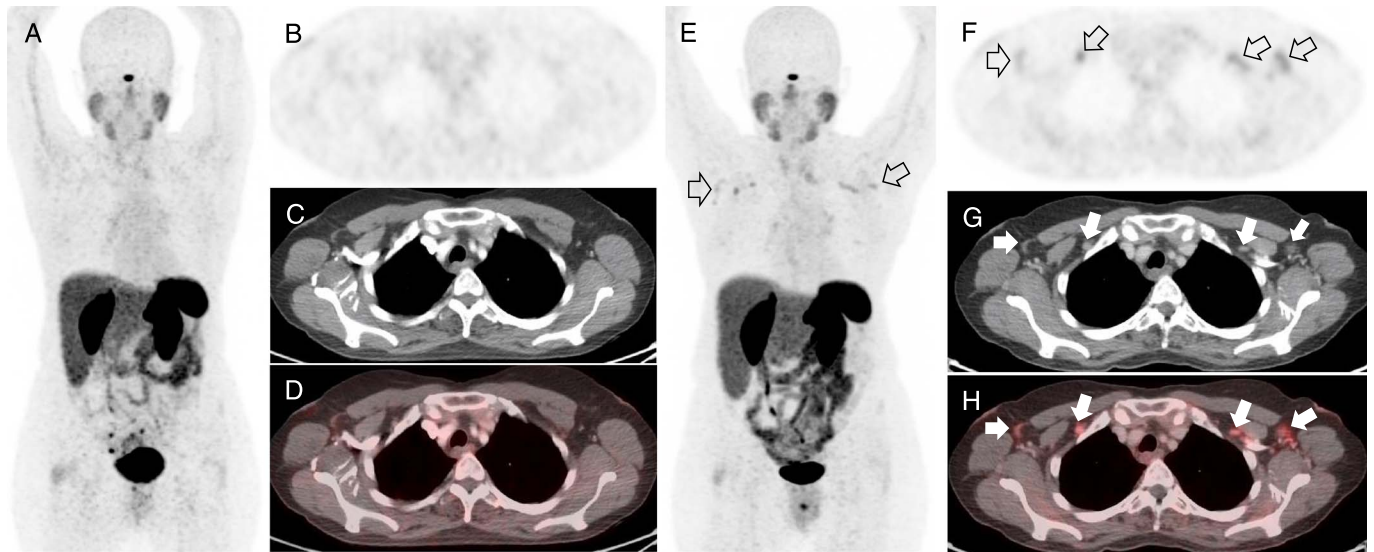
A 64-year-old woman with malignant carcinoid tumor of the ileum received right ileocelectomy 9 years ago. Her series posttherapy follow-up imaging studies have been negative for disease, including the most recent ^{68}Ga -DOTATATE PET/CT scan performed 8 months ago (A: MIP image; B: axial PET; C: axial CT; D: axial fused PET/CT images of the axillary). The current ^{68}Ga -DOTATATE PET/CT images (E: MIP image; F: axial PET; G: axial CT; H: axial fused PET/CT images of the axillary and subpectoral regions) revealed cluster of new DOTATATE-avid bilateral axillary and subpectoral nodes (arrows in E–H, with SUVmax 2.2–3.6). The fatty right axillary lymph node has been stable in size, but with new DOTATATE avidity (SUVmax 2.2). Other lymph nodes are new and subcentimeter in short axis, that is, normal CT morphology. The reference liver background SUVmean was 4.1. There was no other abnormal DOTATATE-avid lesion on PET/CT. Upon further investigation, as documented in the patient's medical records, she received 2 doses of intramuscular injection of Pfizer-BioNTech COVID-19 (coronavirus disease 2019) mRNA vaccine¹: the first dose in the right upper arm 42 days ago and the second dose in the left upper arm 21 days prior to the current PET/CT examination. Thus, the new DOTATATE-avid bilateral axillary nodes are reactive changes rather than metastatic small bowel neuroendocrine tumor. It has been recently reported that COVID-19 mRNA vaccine can induce ipsilateral FDG-avid axillary lymphadenopathy shortly after vaccination,² which shares similar FDG PET/CT findings as other vaccinations such as influenza.^{3–6} This case showed that COVID-19 mRNA vaccination could not only induce new DOTATATE avidity in preexisting axillary lymph node (the right axillary fatty lymph node), but also induce new DOTATATE-avid ipsilateral axillary and subpectoral lymph nodes. Such immune response–induced DOTATATE avidity can be detected up to 42 days after vaccination. This phenomenon suggests a systemic immune-mediated response to the COVID-19 mRNA vaccine, probably similar to that reported in other RNA cancer vaccination.⁷ As millions of people are receiving COVID-19 mRNA vaccination,⁸ it is important for physicians to understand that such vaccination can induce reactive lymph nodes with either FDG avidity or DOTATATE avidity and avoid false interpretation.
